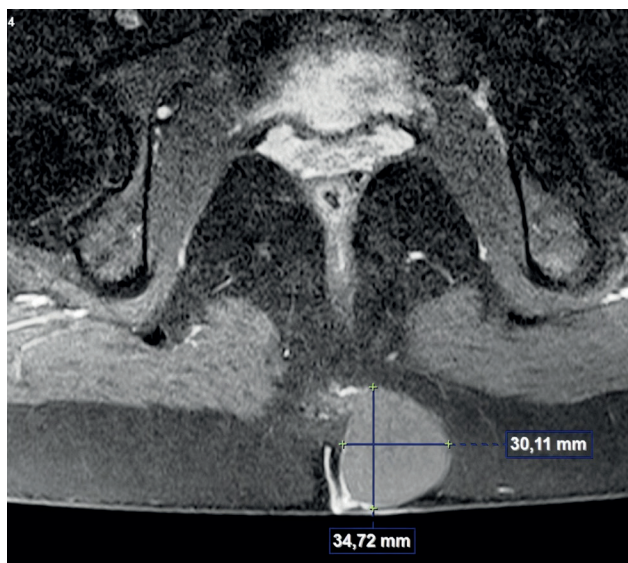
Computed tomography image of epidermal cyst
